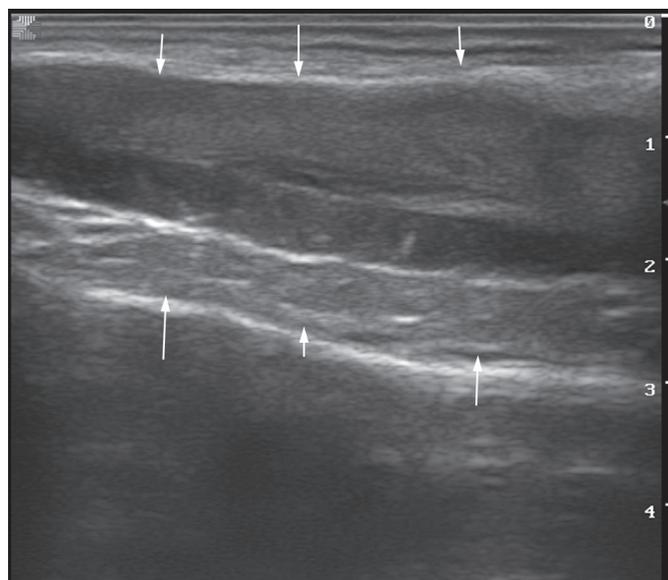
Transrectal ultrasonography of the normal pelvic urethra in a ram
